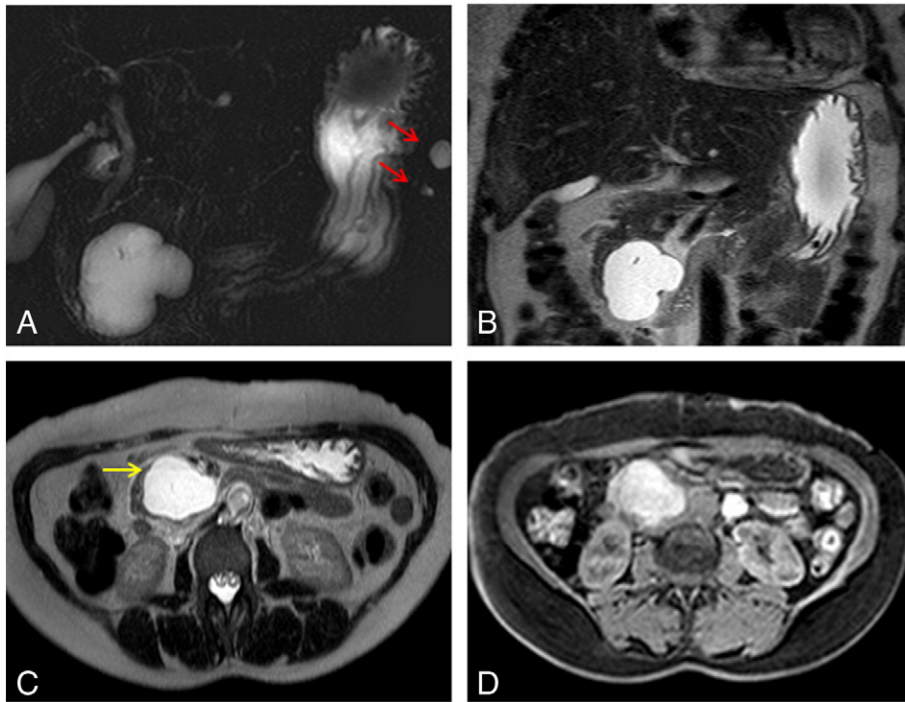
MR imaging firstly performed during the diagnostic workup of the pancreatic cystic lesion. Coronal Magnetic Resonance cholangiopancreatography (MRCP; A) and coronal T2-weighted MR images (B) depict the presence of a unilocular cystic lesion with lobulated contours, located in the pancreatic head. Two smaller lesions are visible in the pancreatic tail (red arrows). Axial T2-weighted (C) and axial unenhanced fat-suppressed T1-weighted (D) MR images. The high signal intensity of the cystic fluid on T1-weighted MR image suggests a proteinaceous/hemorrhagic component. An intracystic fluid-fluid level is observed on T2-weighted MR images (yellow arrow).
